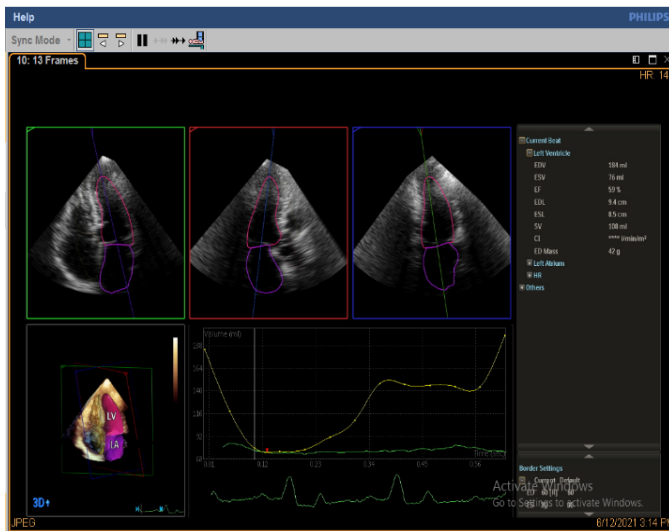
3D Echocardiographic default data of case number 1 [before manual optimization].
